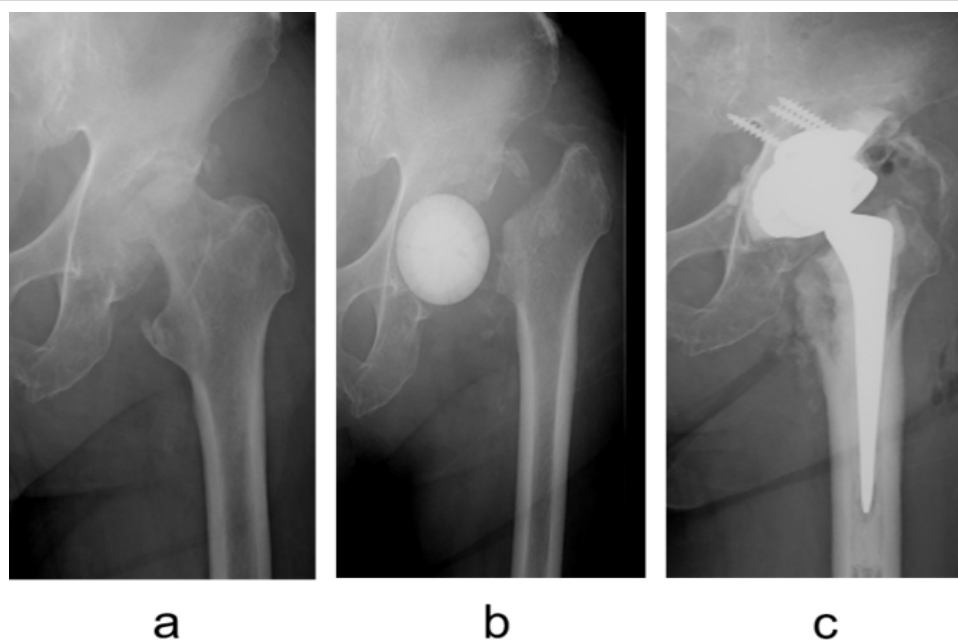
(a) Radiograph obtained at the initial visit showing collapse of the left femoral head and an acetabular bone defect. (b) Post-operative radiograph showing implantation of the double-layered antibiotic-loaded cement spacer within the hip joint. (c) Post-operative radiograph showing implantation of the double-layered antibiotic-loaded cement spacer within the hip joint.
